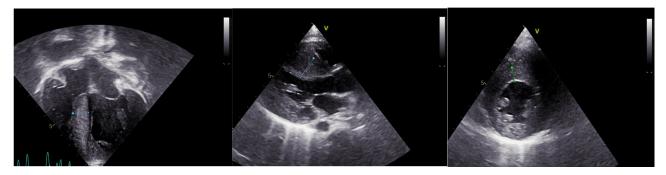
Echocardiographic images showing severe hypertrophic cardiomyopathy. The interventricular septum measures 1.2 cm, 1.8 cm, and 1.0 cm in images 1, 2, and 3 respectively.
